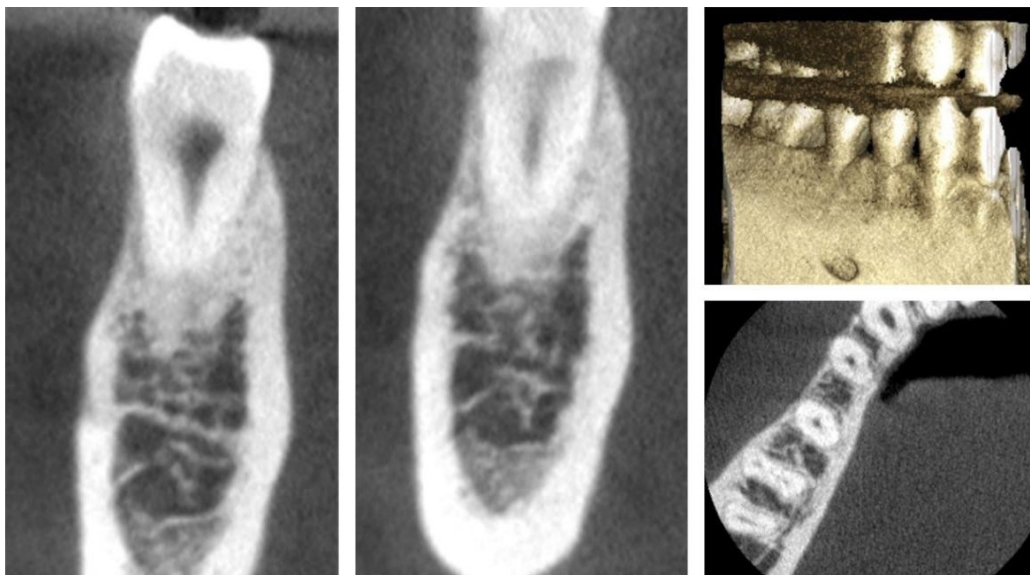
CBCT findings consistent with regeneration of the buccal bone and presence of periodontal ligament space.
